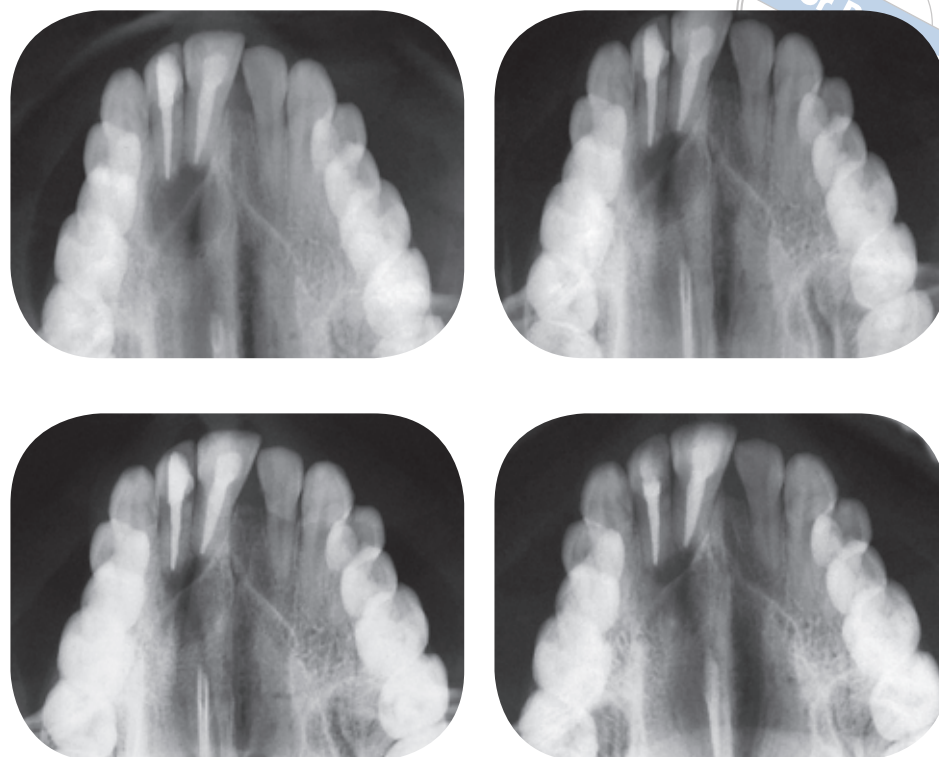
Radiographs taken at baseline, 3, 6 and 9 months.
